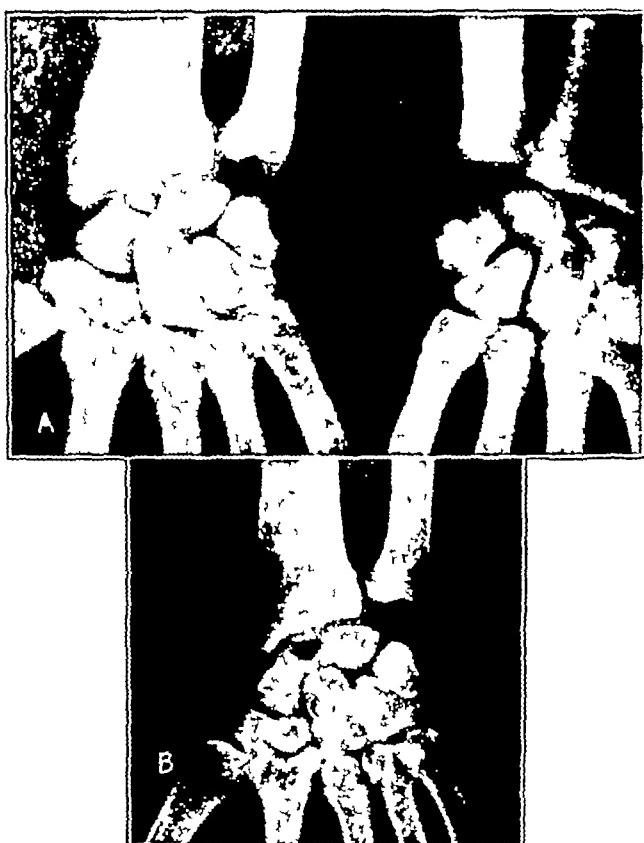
(case 1).—*A*, roentgenogram taken twenty-two months after injury, showing nonunion fracture of the proximal pole of the scaphoid. *B*, ten days after excision of the small proximal fragment. The general alignment of the proximal carpal bones has not been disturbed.
